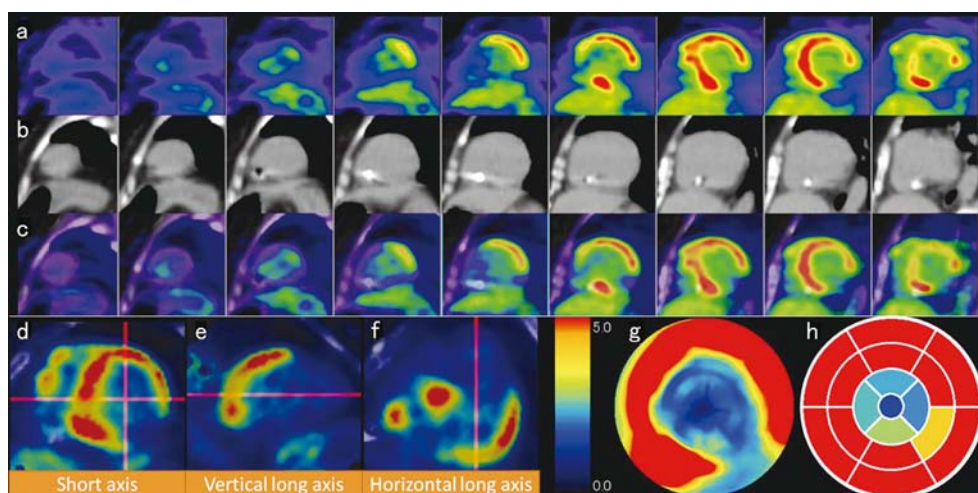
Polar map and 17-segment model of cardiac ^{18}F -FDG uptake. Short-axis images of an ^{18}F -FDG PET (a), CT (b), and fused PET/CT image (c) are displayed on the upper panel. Noticeably high uptake is seen at the mid- to basal level of the left ventricle except for the inferior to inferolateral wall. There is also focal uptake on the right ventricle due to the patient's active cardiac sarcoidosis. Fused images (d-f) are useful to make a polar map (g) and to display the SUVmax in a 17-segment model.
